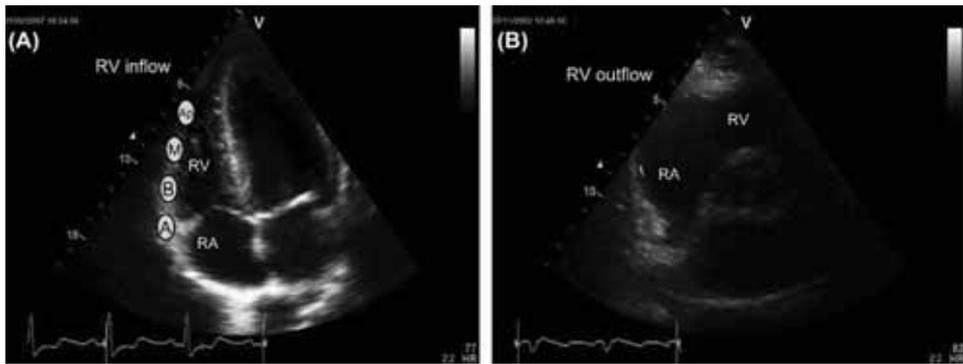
Panel A: The RV viewed from apical four-chamber view with the RA (right atrium) and the inflow tract of the RV. Panel B: The RV is viewed from parasternal short axis view with RV outflow tract visualised. (A) - annular level; (B) - basal level; (M) - mid level; (Ap) - apical level.
